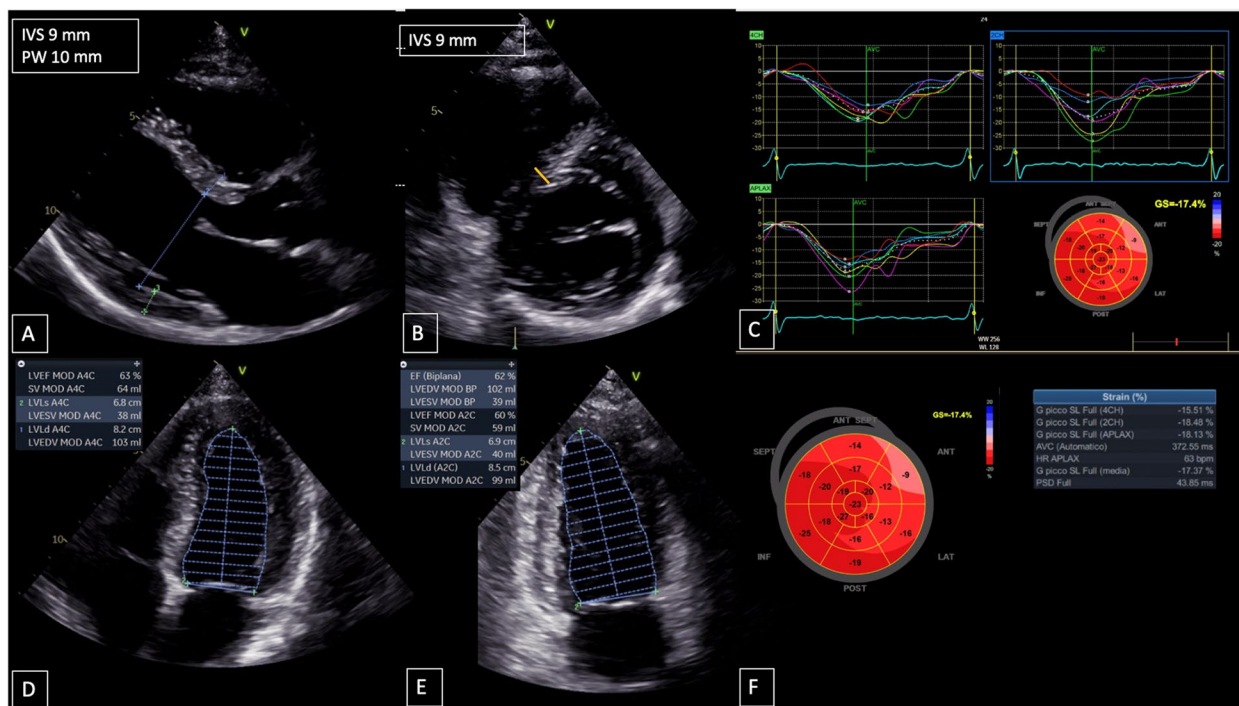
Echocardiogram at 6 months of follow-up documented reduction in LV wall thickness within normal values (A, B), improvement in LV ejection fraction (EF 63%) using Simpson's biplane method (D, E), and improvement in GLS to -17.4% (C, F)
